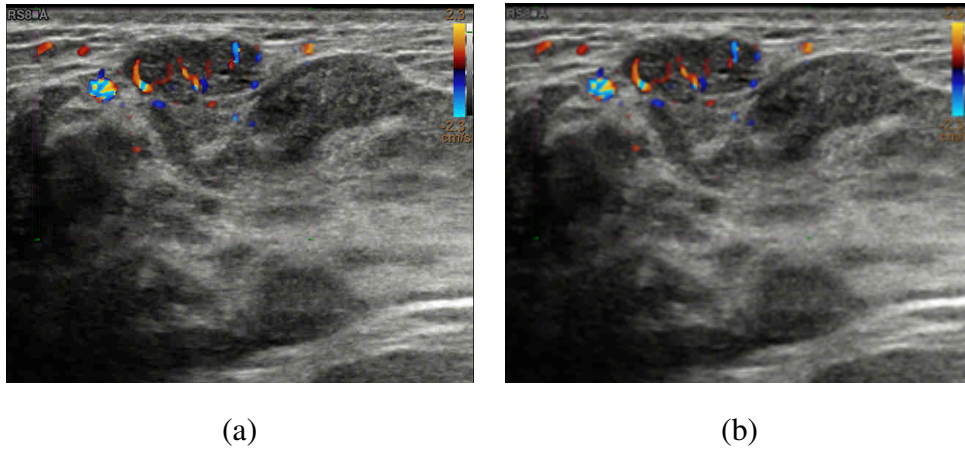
(a) Original Elastography. (b) The result of image registration between conventional US and Power Doppler.
